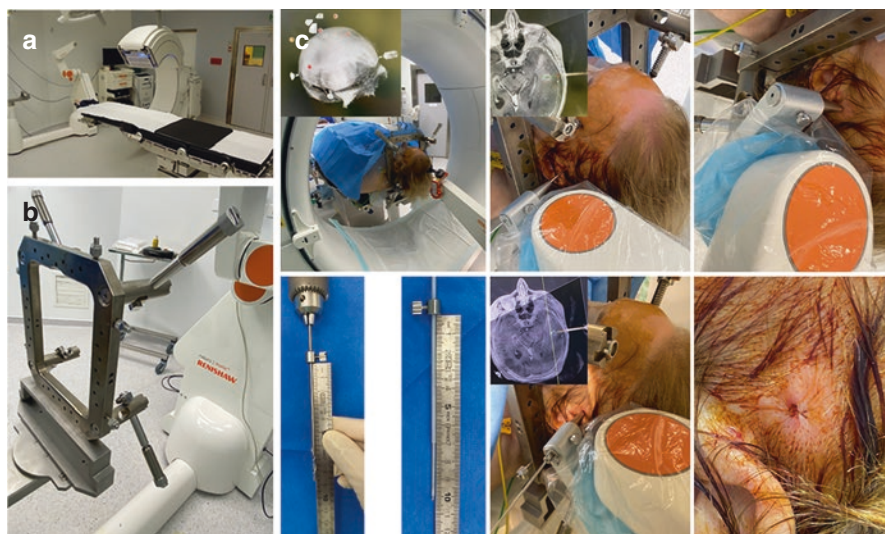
Presentation of the current surgical procedure of robot-assisted stereotactic biopsy. From left to right and top to bottom: (a) general presentation of the operating room with the mobile CT unit O-Arm and the robot NeuroMate, (b) close-up on the Talairach stereotactic head clamp composed by the base of the Talairach frame, (c) first step of the procedure with a 3D series acquisition of the Neurolocate tool locked on the robot arm and moved close to the patient's head, control of the correct robot's positioning with a new 3D series and a metallic punch, robot arm positioned against the patient's skin to minimize the mechanical deviation, fine adjustment of the drill with a mechanical stop, adjustment of the monopolar coagulation 10 mm below the dura mater plane, intraoperative control of the needle position into the patient head with a third O-Arm acquisition, puncture wound closed with absorbable suture (minimal shaving)
